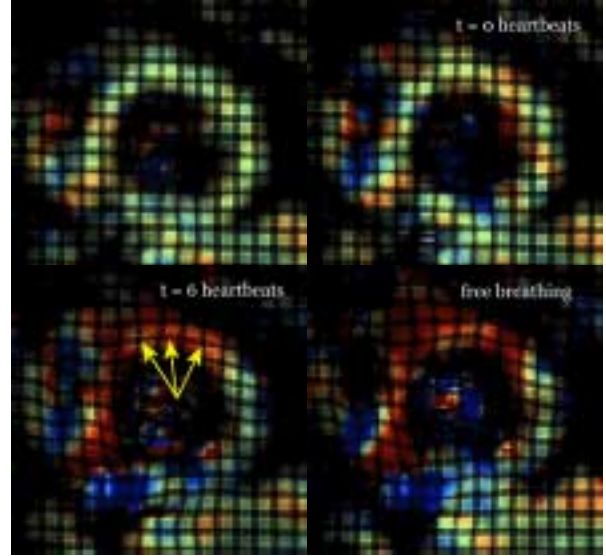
Pseudocolor end-systolic circumferential strain map from HARP MRI overlaid on end-diastolic synthetic tag image prior to LAD coronary artery occlusion (top left), at start of occlusion (top right), 6 heartbeats after occlusion (bottom left), and during free breathing (bottom right). The color scale ranges from increased shortening (blue) to no change in shortening (green) to decreased shortening (red). The induced ischemia was detected as a red area at 10 seconds after coronary artery occlusion. The septal wall is from 9 o'clock to 12 o'clock
